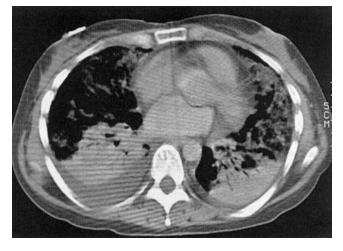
CT section of chest in a patient with ARDS that demonstrates dependent consolidation and areas of normal lung and atelectatic lung in the mid and anterior zones.
